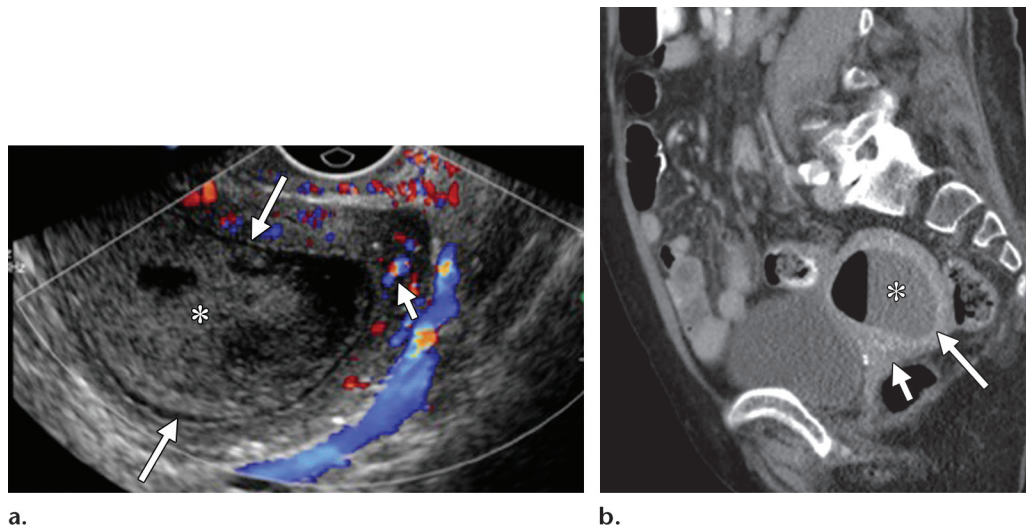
Late PID: pyometra in a 52-year-old woman presenting with cervical motion tenderness and a thick yellow vaginal discharge. (a) Sagittal transvaginal color Doppler US image shows complex heterogeneous fluid (*) within a markedly dilated endometrial canal (long arrows) and hyperemia of the adjacent myometrium (short arrow). Uterine wall thinning is apparent. (b) Sagittal contrast-enhanced CT image from the same date shows a distended uterus (long arrow) containing complex fluid and an air-fluid level within the endometrial canal (*), hyperemic endometrium, and fat stranding and pelvic edema in the vesicouterine pouch (short arrow), findings compatible with endometritis and pyometra.
